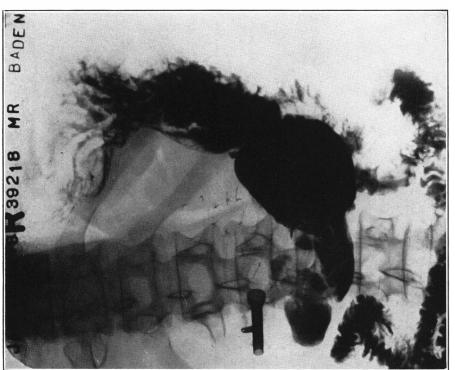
A case of chronic pancreatitis with stricture of the terminal common bile duct in which a choledochoduodenostomy was performed with the aid of a vitallium tube. X-rays show the tube in place and the regurgitation of air and barium into the common bile duct and its branches.
